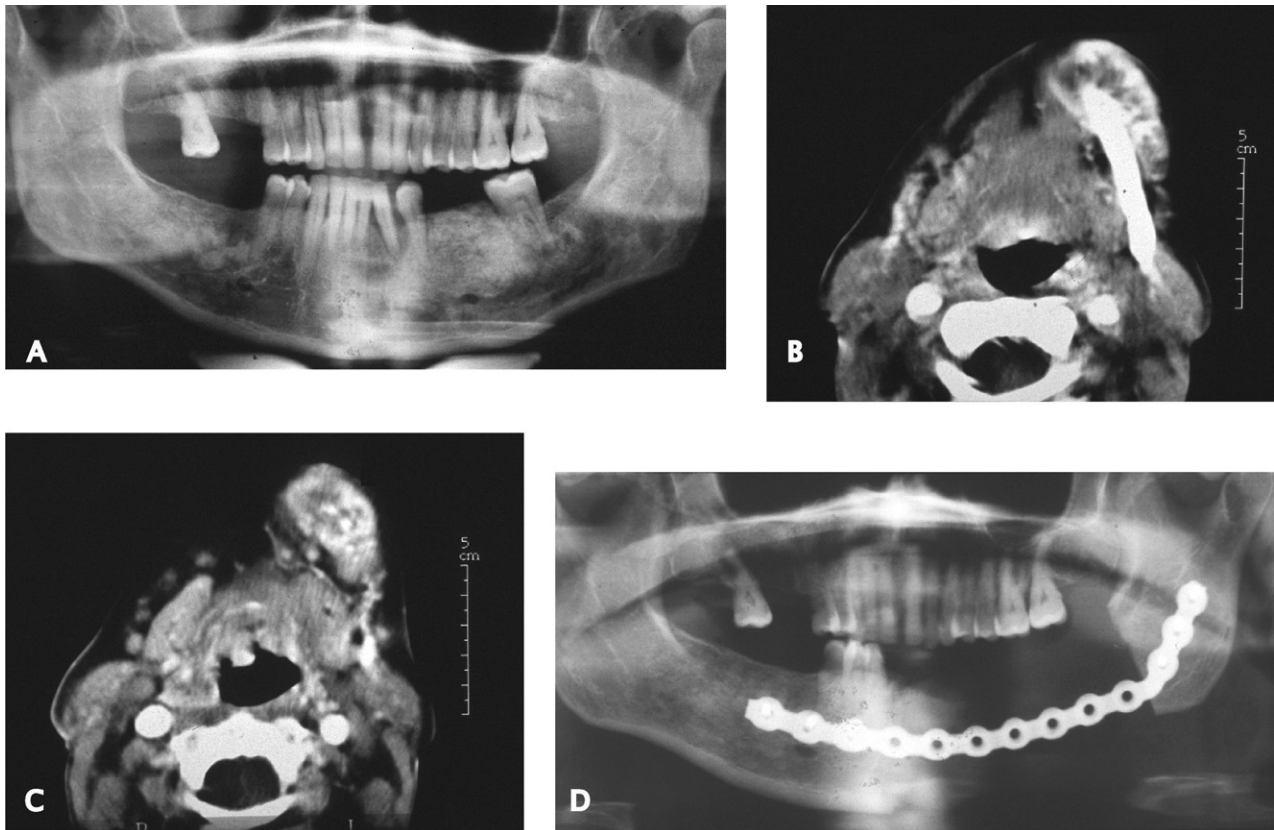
A, The preoperative orthopantomogram shows an ill-defined chondroid lesion along the left side of the mandibular symphysis with cortical breakthrough and periostitis. B, The preoperative axial computed tomography scan of the same patient shows a solid tumor with chondroid matrix (devoid of osteoid matrix) and a thick cartilaginous cap with areas of calcification and aggressive features as detailed on the radiograph as well as soft tissue extension. C, Computed tomography scan of the same patient demonstrates local recurrence of the aggressive chondroid tumor with similar imaging features status post curettage of the primary tumor. D, Follow-up orthopantomogram of the same patient after subsequent wide local resection and reconstruction without evidence of local recurrence.
